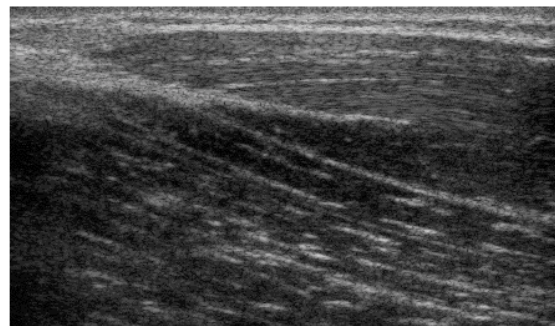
Ultrasound image of the distal biceps brachii ; the distal tendon (upper left) continues as an internal aponeurosis. Fascicles are visible inserting into the aponeurosis.
